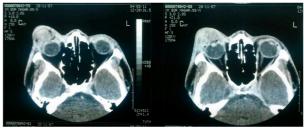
The computed tomography scan of the orbit showing homogenously enhanced hyperdense tissue involving the anterior and lateral aspect of pre-septal space of right orbit.
